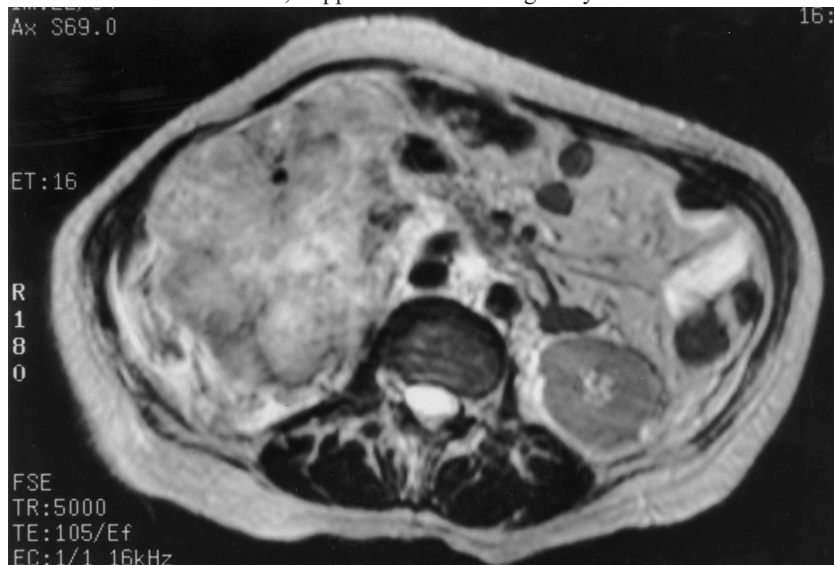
T2-weighted magnetic resonance image of a transverse section through the abdomen at the level of the highly vascular right renal mass.
